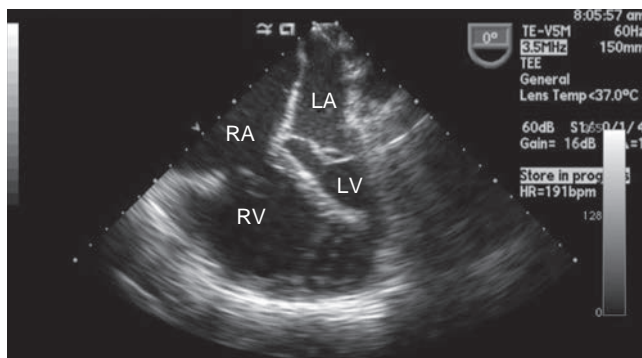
Transesophageal echocardiogram in a patient with acute pulmonary embolus. The midesophageal four-chamber view shows severe dilation of the right ventricle (RV) and right atrium (RA), indicating RV failure. There is bowing of the ventricular and atrial septae toward the left ventricle (LV) and left atrium (LA). Severe compression of the LA and LV causes decreased filling and poor function of those chambers.
